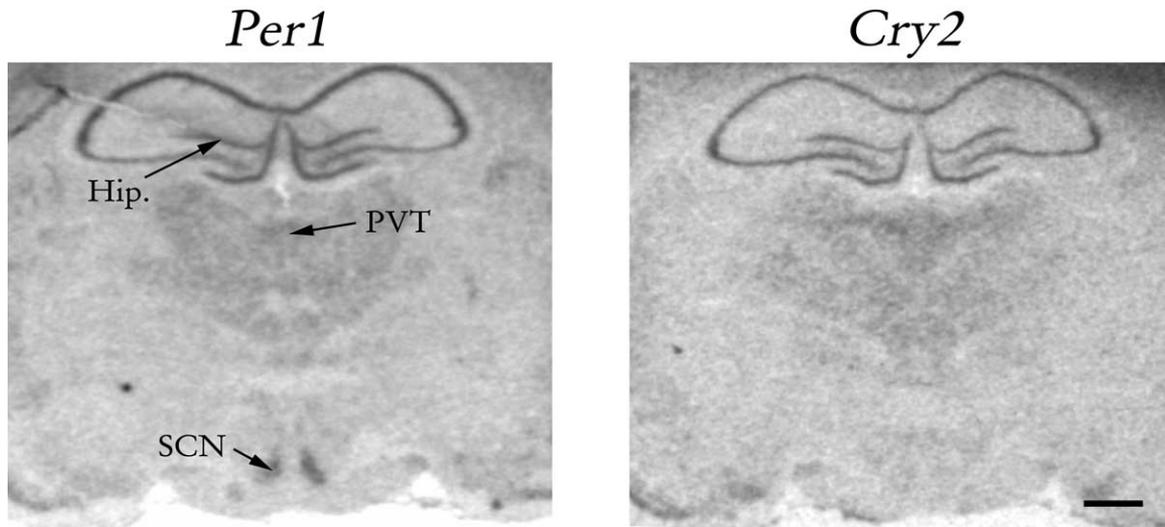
Representative examples of *Per1* and *Cry2* mRNA expression in coronal sections at the level of the suprachiasmatic nucleus (SCN), hippocampus (Hip.) and paraventricular thalamic nucleus (PVT) in *Arvicanthis* at CT 04. Scale bar=1 mm.
